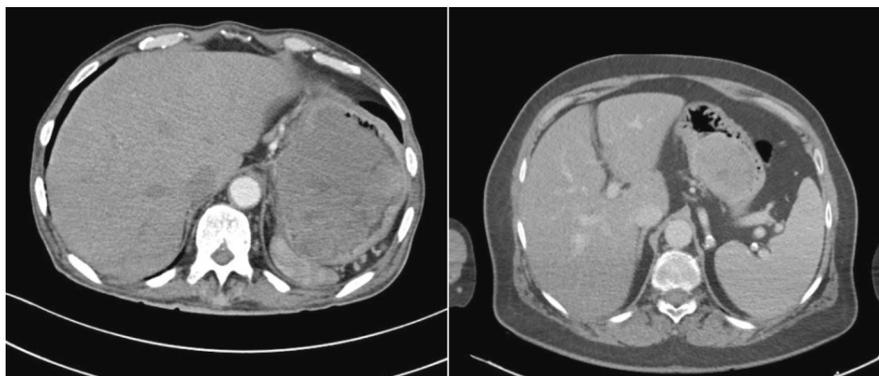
CT images of two patients'.
